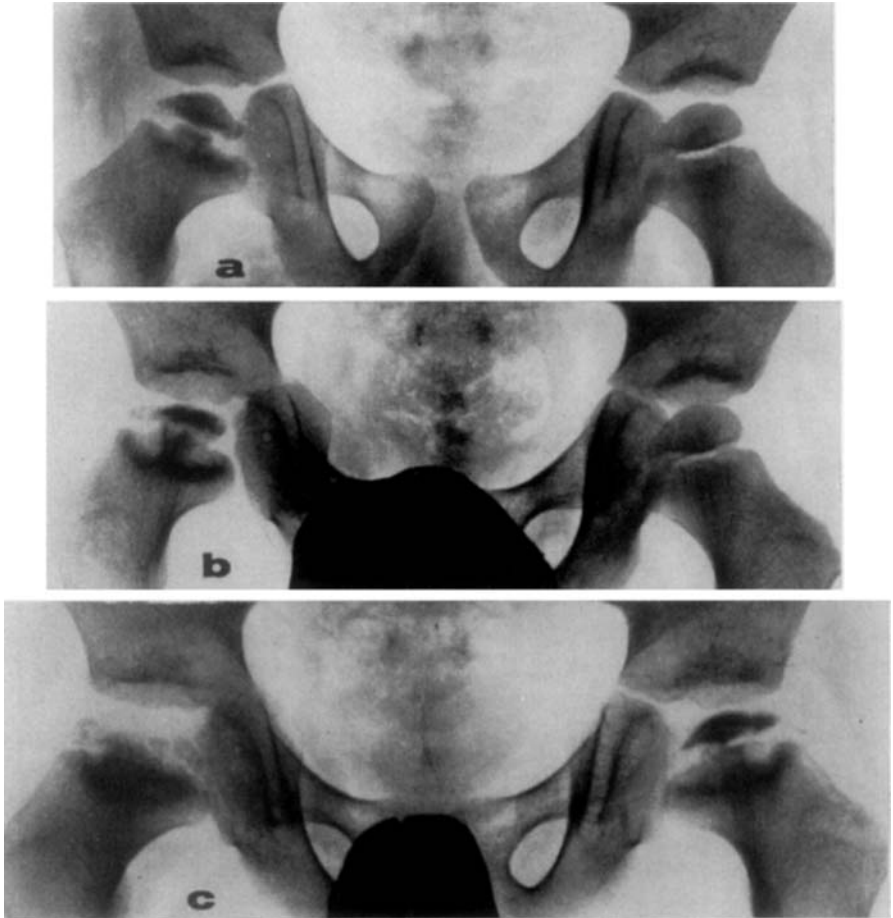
Case 44, boy aged 4 at onset. The radiographs demonstrate severe, symmetrical metaphyseal changes with circular defects in the periphery of the proximal metaphyseal surfaces and plateau-shaped elevations in the central portions of the latter. Total necrosis of the epiphysis. *a:* 6 months after onset. *b:* 10 months after onset. *c:* 23 months after onset. Treated at first with Thomas' splint on the right side, then by bed rest for one and a half year and finally with Thomas' splint on the left side. End-result elliptical head on both sides.
